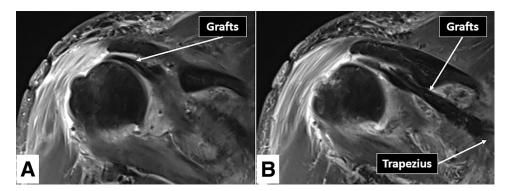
Oblique coronal view magnetic resonance imaging of right shoulder indicating the grafts in the subacromial space (A) and the infraspinatus fossa (B).
